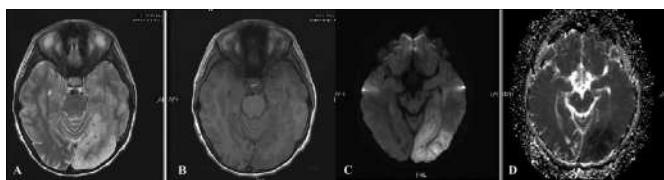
T2, T1 images of MR brain done a year later revealed signal abnormality in the left parieto-occipital lobe along with diffusion restriction in this area on DWI and dropout on ADC mapping.
